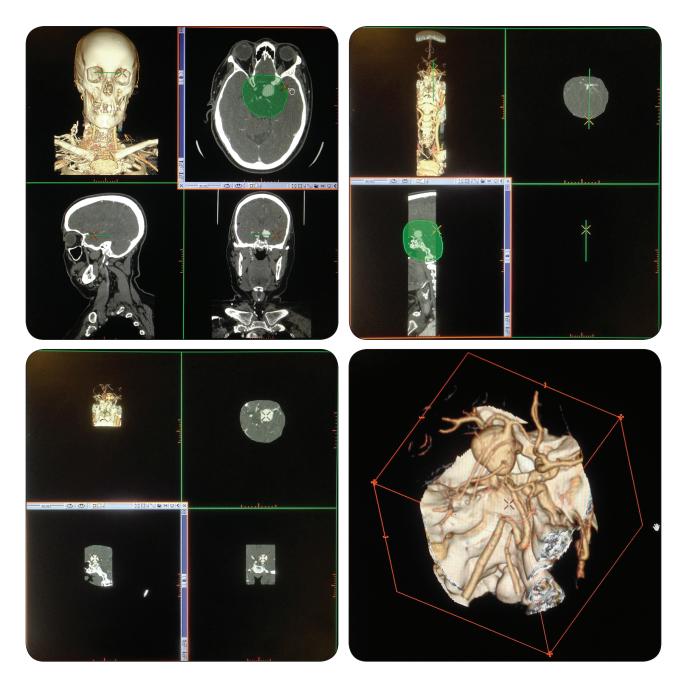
First steps in post-processing a CTA study. The process is most efficient when 'trimming' begins in a standard plane of section, proceeds to the other planes, and then addresses a simplified 3DVR.
